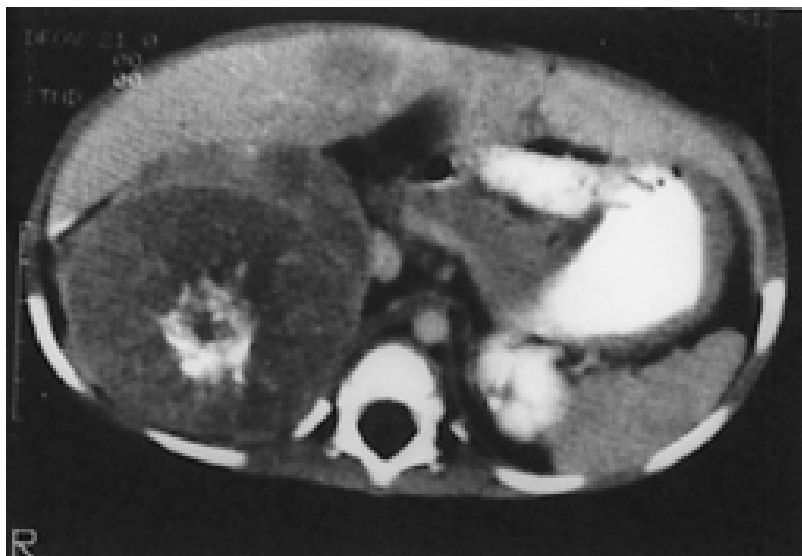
Computed tomography scan demonstrating calcifications within a neuroblastoma.
